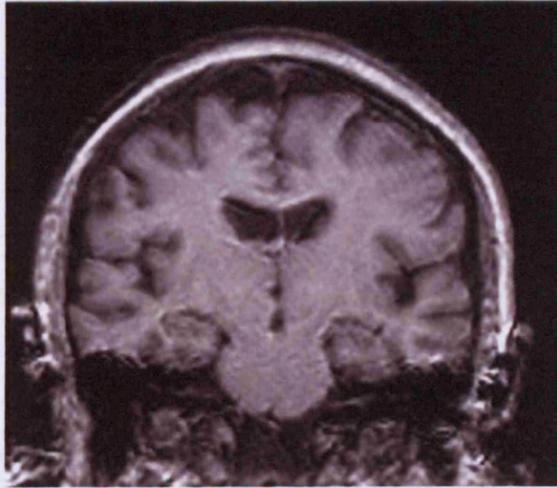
A coronal MR image showing movement artefact
